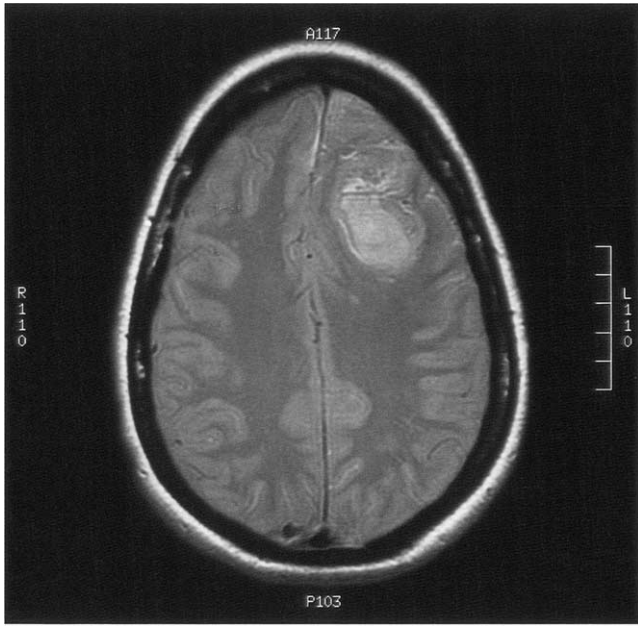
Magnetic resonance image demonstrating a large left frontal intraparenchymal hemorrhagic lesion with regional mass effect.
